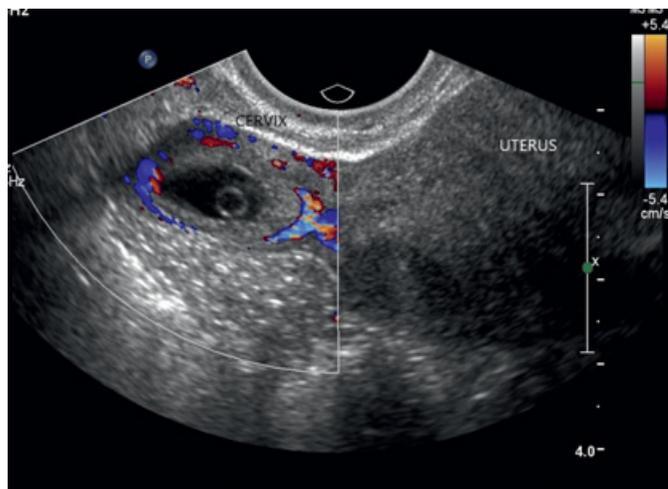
Ultrasound image of a cervical pregnancy. (Image kindly provided by Dr. Timothy Canavan, MD MSc – Chair, ETSU Quillen College of Medicine Department of Obstetrics and Gynecology.)
